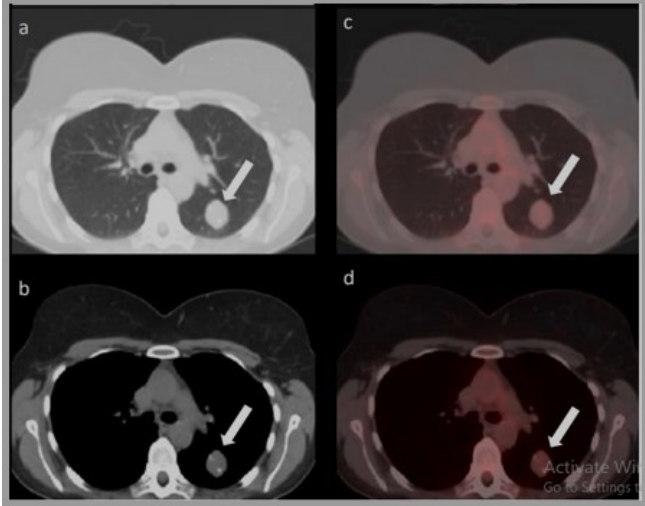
y.o female with incidental finding on chest CT, LUL SPN without increased metabolic activity suggesting benign process, follow up recommended. CT (a,b) and fused PET/CT (c,d) images;
